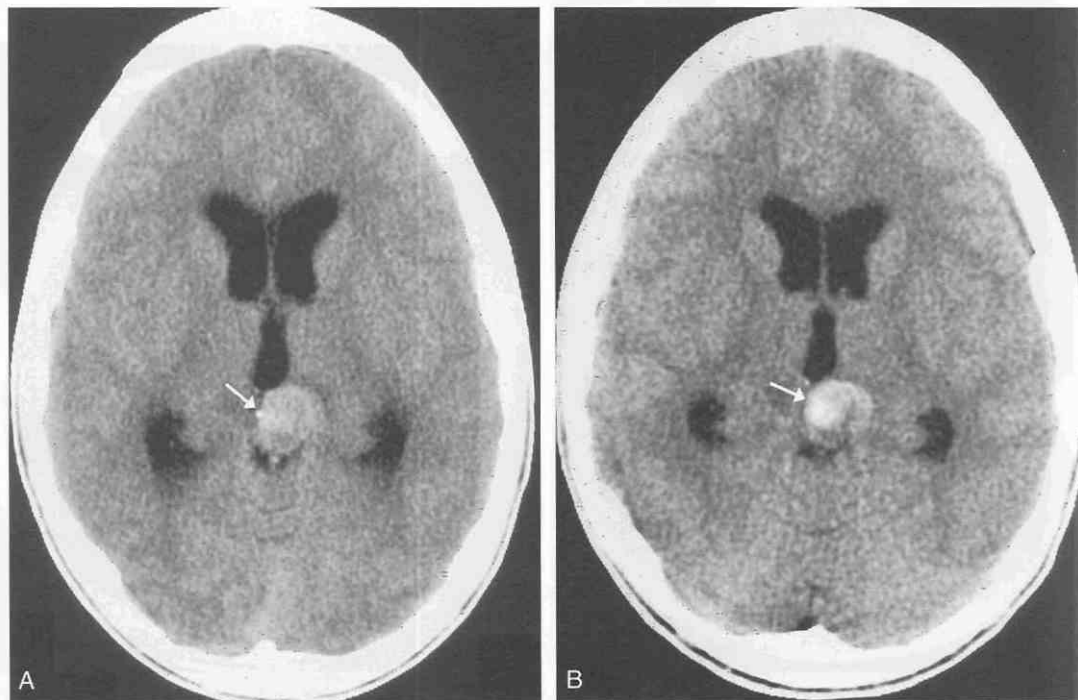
Germinoma of the pineal region. *A*, Axial CT image demonstrates a well circumscribed round hyperdense mass in the pineal region extending slightly to the left and indenting the posteromedial aspect of the left thalamus (arrow) with a thin hypodense rim (likely representing edema) at the interface with the left thalamus. *B*, Following intravenous contrast administration, the mass demonstrates diffuse contrast enhancement (arrow).
